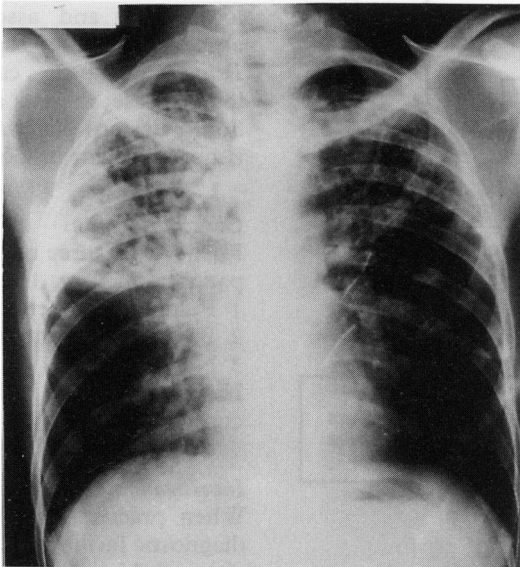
Chest radiograph showing bilateral upper and mid-zone shadowing and consolidation, more marked on the right.
